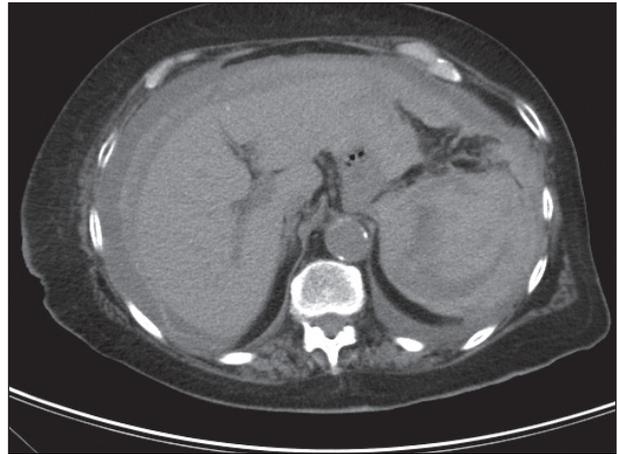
CT scan abdomen axial image showing enlarged spleen, subcapsular haematoma, peri-splenic haemorrhage and haemoperitoneum
